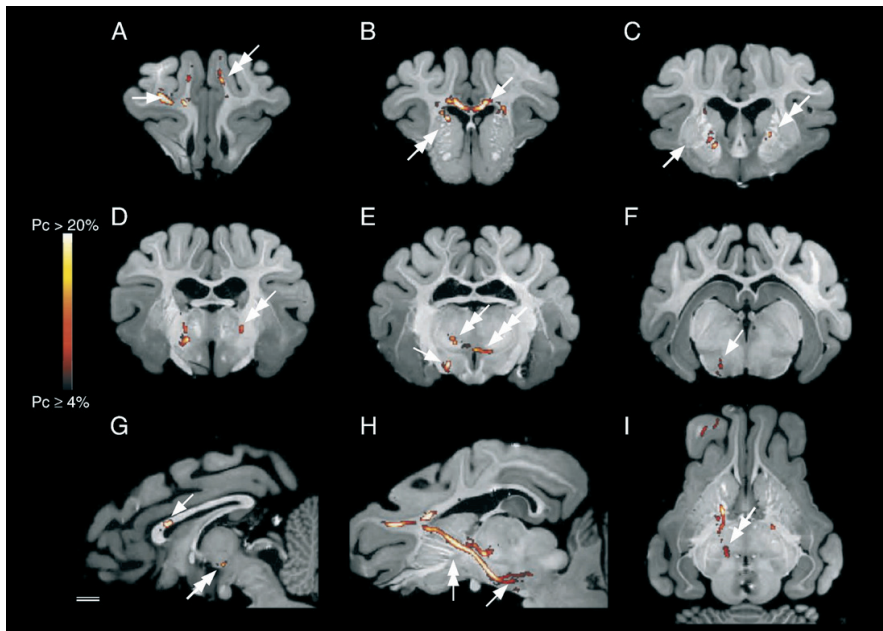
In vitro probabilistic tractography seeded in the right SC of brain 1 and constrained using waypoint regions. The (probabilistic) fiber tracts are overlaid on the high resolution in vitro MPRAGE MRI seen in coronal (A–F), sagittal (G, H) or horizontal section plane (I). The right side of the brain is depicted in the left side of the figures. The color bar represents the probabilistic connectivity index of the fiber tracts. Tractography from the SC (A, arrow) revealed a fiber tract towards the contralateral PFC (A, double arrow) and SC crossing through the caudal part of the genu of the pallidum (G, arrow). Ipsilaterally, several segregated fiber tracts were observed passing through the medial and dorsal part of the capsula interna (B, H, double arrow). Tractography did not include the putamen (C, arrow) or the pallidum. Tractography entered the rostral part of the thalamus and eventually the VP and VPL nuclei (E, I, double arrow) before continuing (E, triple arrow) onto the contralateral hemisphere (C, D, G double arrow). Other fiber tracts were directed towards the SN (E, F, H arrow) or further caudally along an alternative fiber tract. Scale bar = 5 mm.
